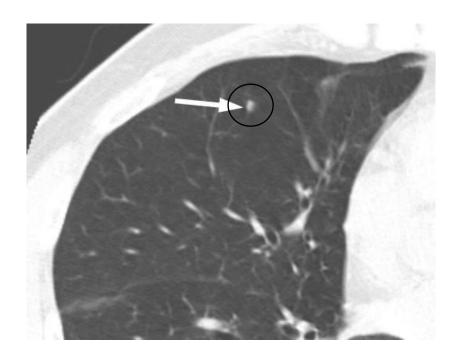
CT scan for nodule detection
